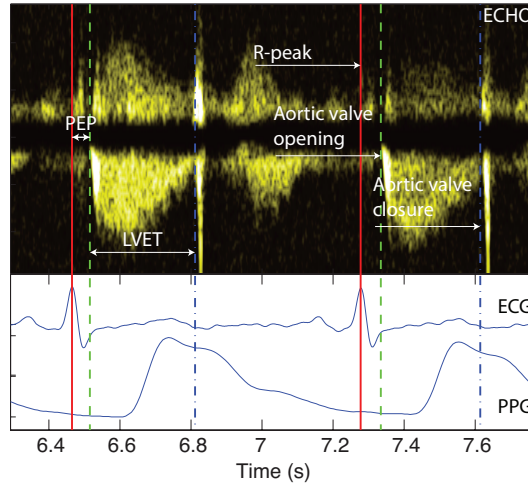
Annotation of aortic valve timings using Doppler mode ECHO.
